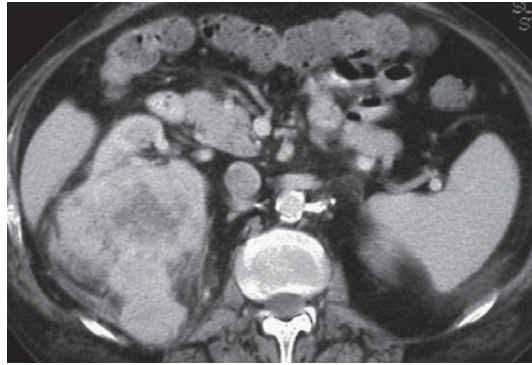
Computed tomography. Renal cell carcinoma. Stage T4 lesion of the lower renal pole with invasion of the paravertebral musculature
